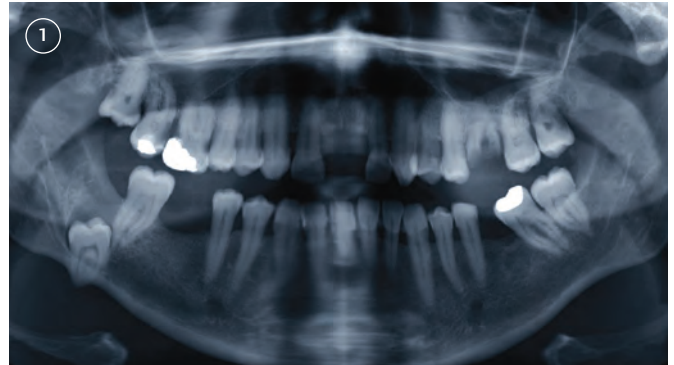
Baseline orthopantomograph showing displaced tooth 48 and associated radiolucency.
